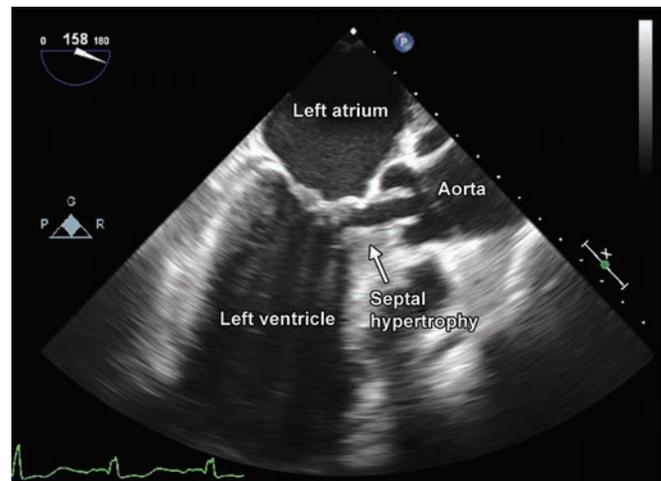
Two dimensional transesophageal long axis view at 120 degrees.
